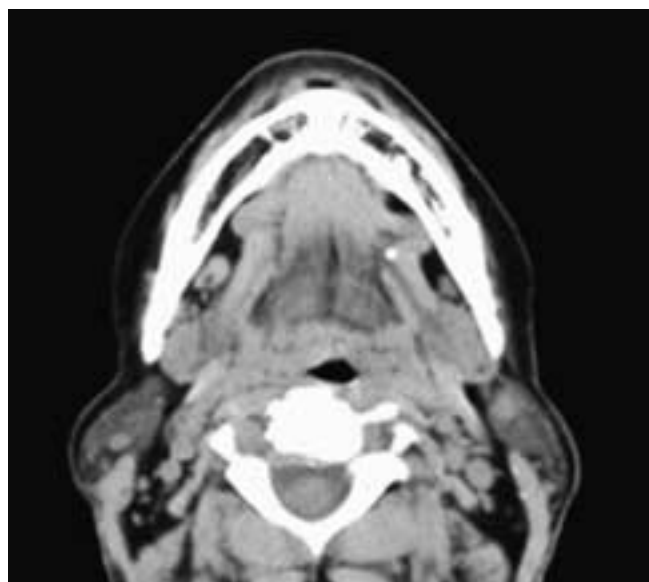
Axial CT scan shows a small calculus in the midportion of the left Wharton's duct. The duct is obstructed and dilated proximal to this stone. This patient had submandibular sialolithiasis and early sialadenitis.
